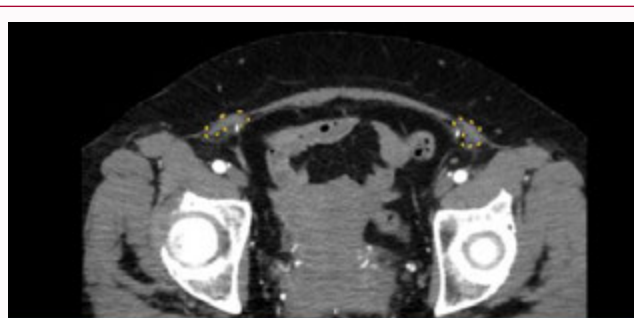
Patient's CTA. Dashed yellow line is marking the prolene mesh. The hyperdense vessels bilateral which are seen right at their entrance point to the mesh are deep inferior epigastric arteries.
